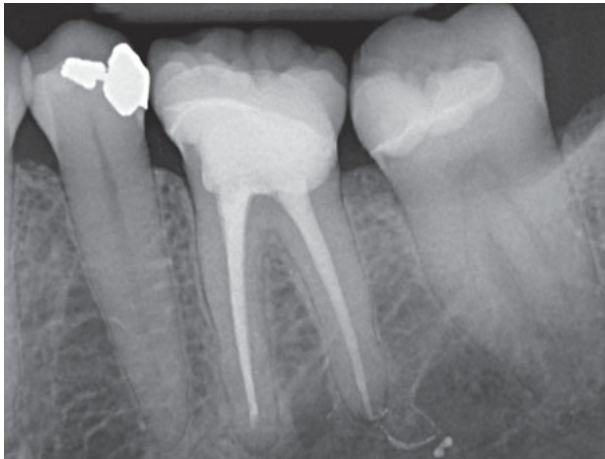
Immediate radiographic control.
